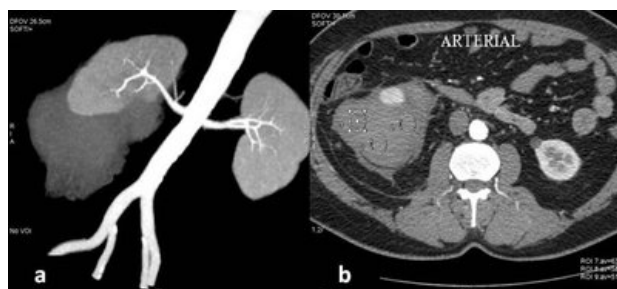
A. Computed tomography (CT) scan reconstructed image of right kidney with perirenal hematoma; B. Cross section CT image during arterial phase showing non-enhancing perirenal hematoma with no other obvious abnormality in the kidney.
